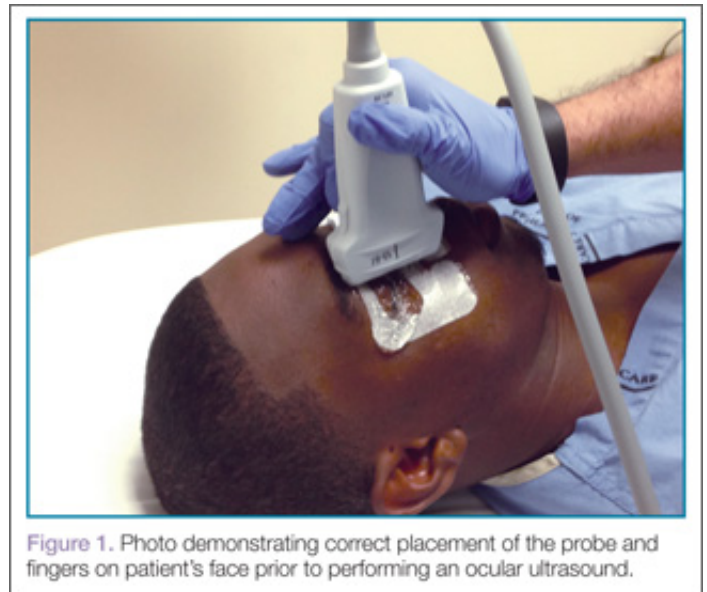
Photo demonstrating correct placement of the probe and fingers on patient's face prior to performing an ocular ultrasound.
